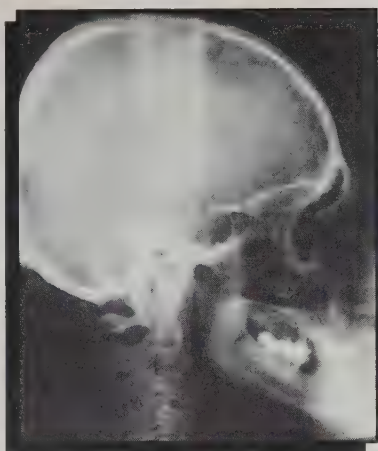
Lateral cephalometric radiograph demonstrating the bony and soft tissue deformity of the patient in Fig. 2. Note gross overclosure.
